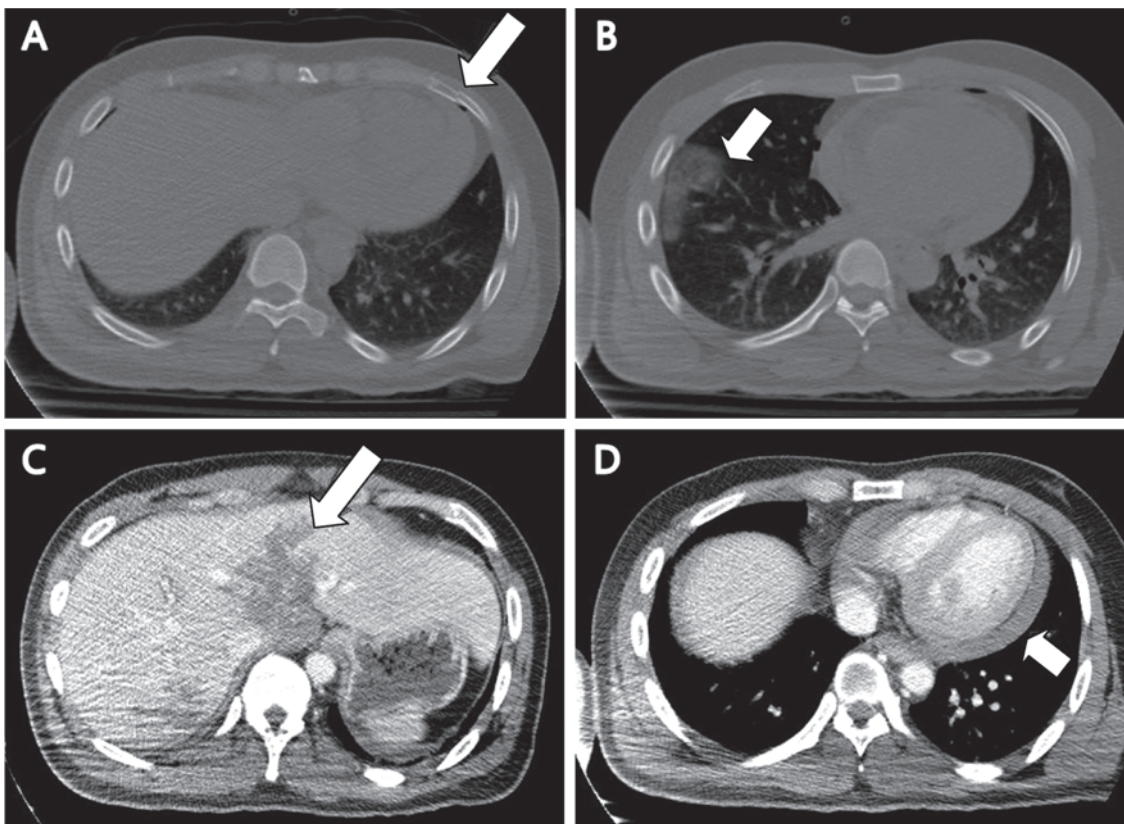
CT findings showing contusion of lung with pericardial effusion, a liver laceration with minimal haemoperitoneum, and a fracture of the left fifth rib (white arrows).
